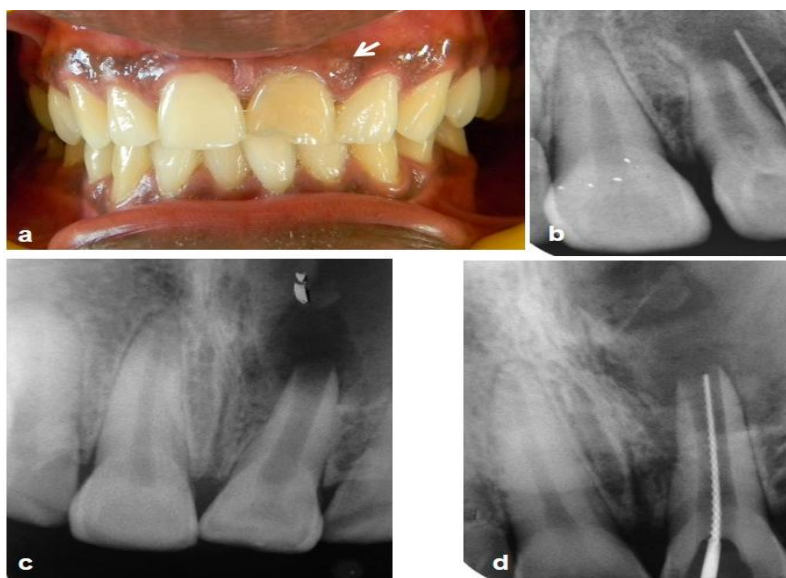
Pre operative (a) photograph showing discoloured maxillary left central incisor with draining sinus tract [marked with white arrow]; (b) radiograph showing a maxillary left central incisor with a gutta-percha Cone tracing the sinus tract; (c) radiograph showing open apex and large periapical lesion in relation to 21; (d) working length determination
